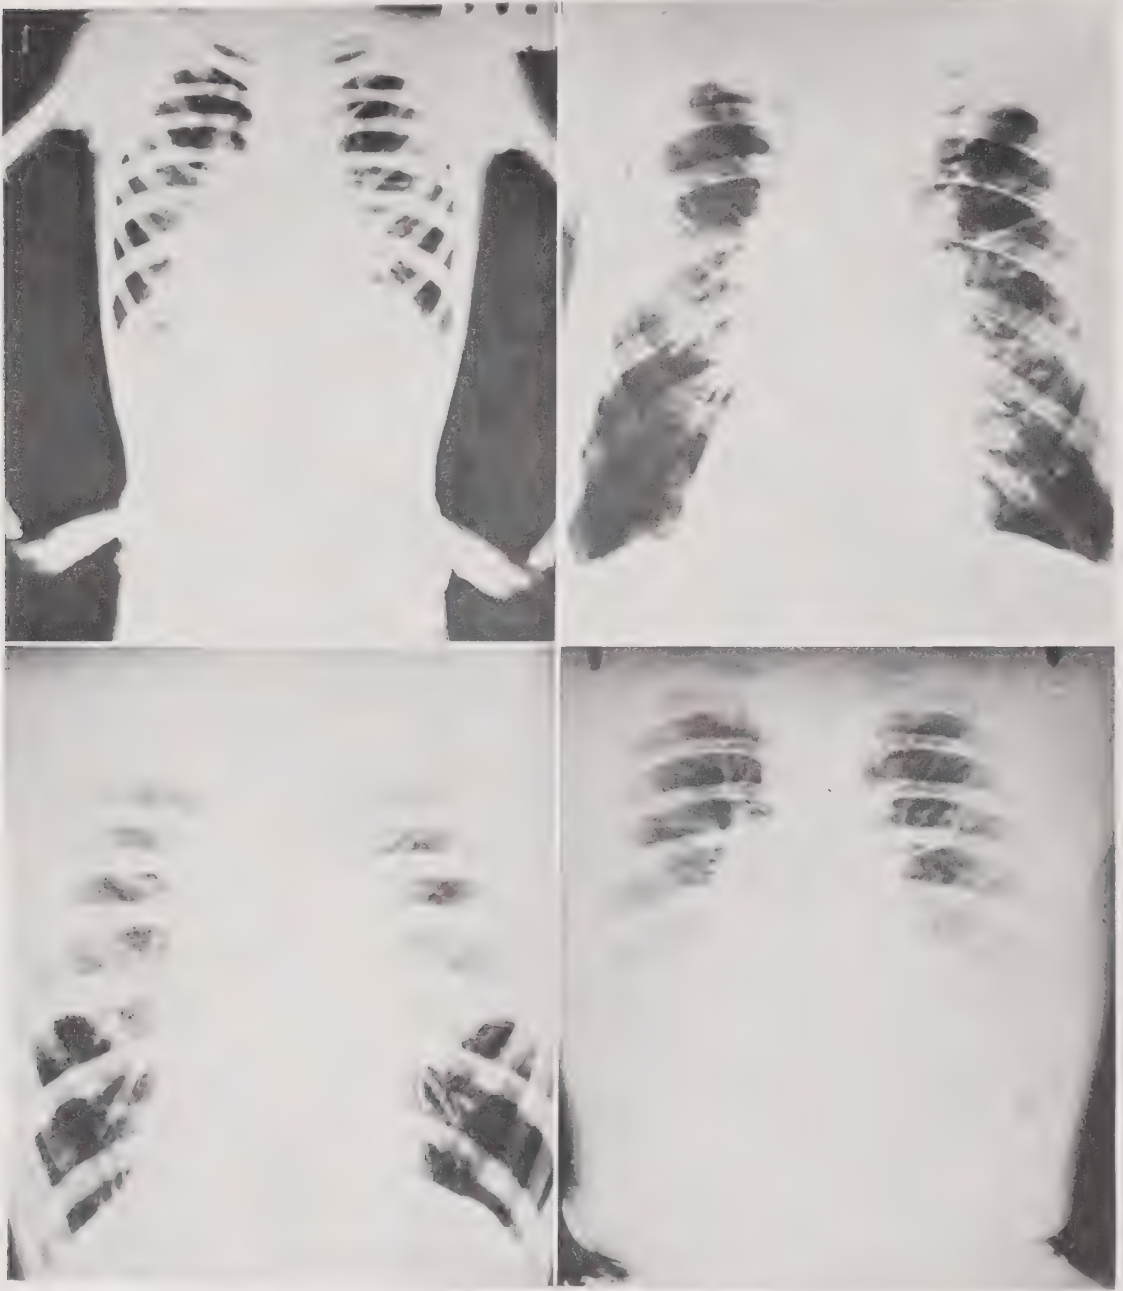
Types of roentgen findings. Upper left: increased hilus shadows with emphysema. Upper right: emphysema with some thickening of upper mediastinal shadow due to hilus shadows. Lower left: peribronchial thickening with increase in hilus shadows and bronchiectasis, especially in the left lower lobe. Lower right: increased bronchial arborization to left upper and both lower lobes. Increased shadow at bases is due to large breasts, not fluid. In all pictures, patient's left side is to reader's left.
